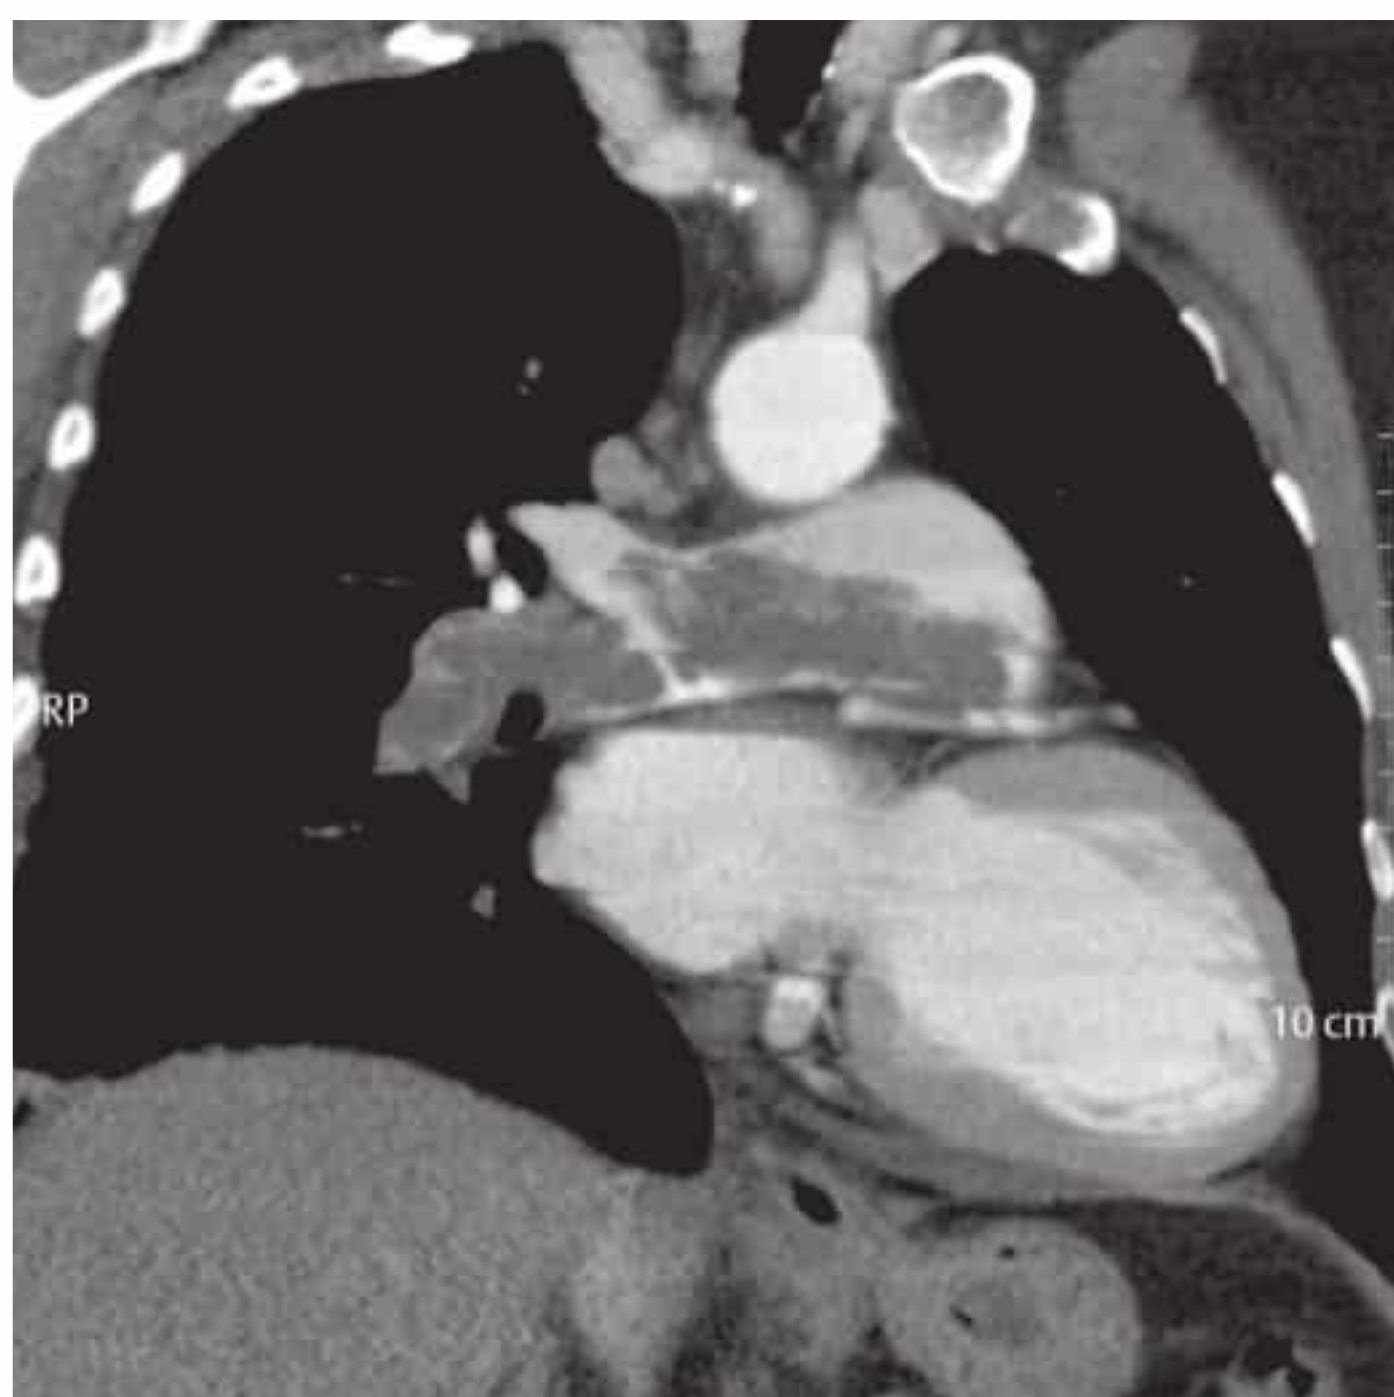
Tumor of the pulmonary artery. Coronal reformatted CTA image. The hypodense material in the central pulmonary arteries, with extension into the right pulmonary artery, is easily misinterpreted as thrombotic material. The material in this case is a pulmonary artery sarcoma. Differentiation is aided by contrast medium enhancement of the sarcoma on delayed postcontrast images.
